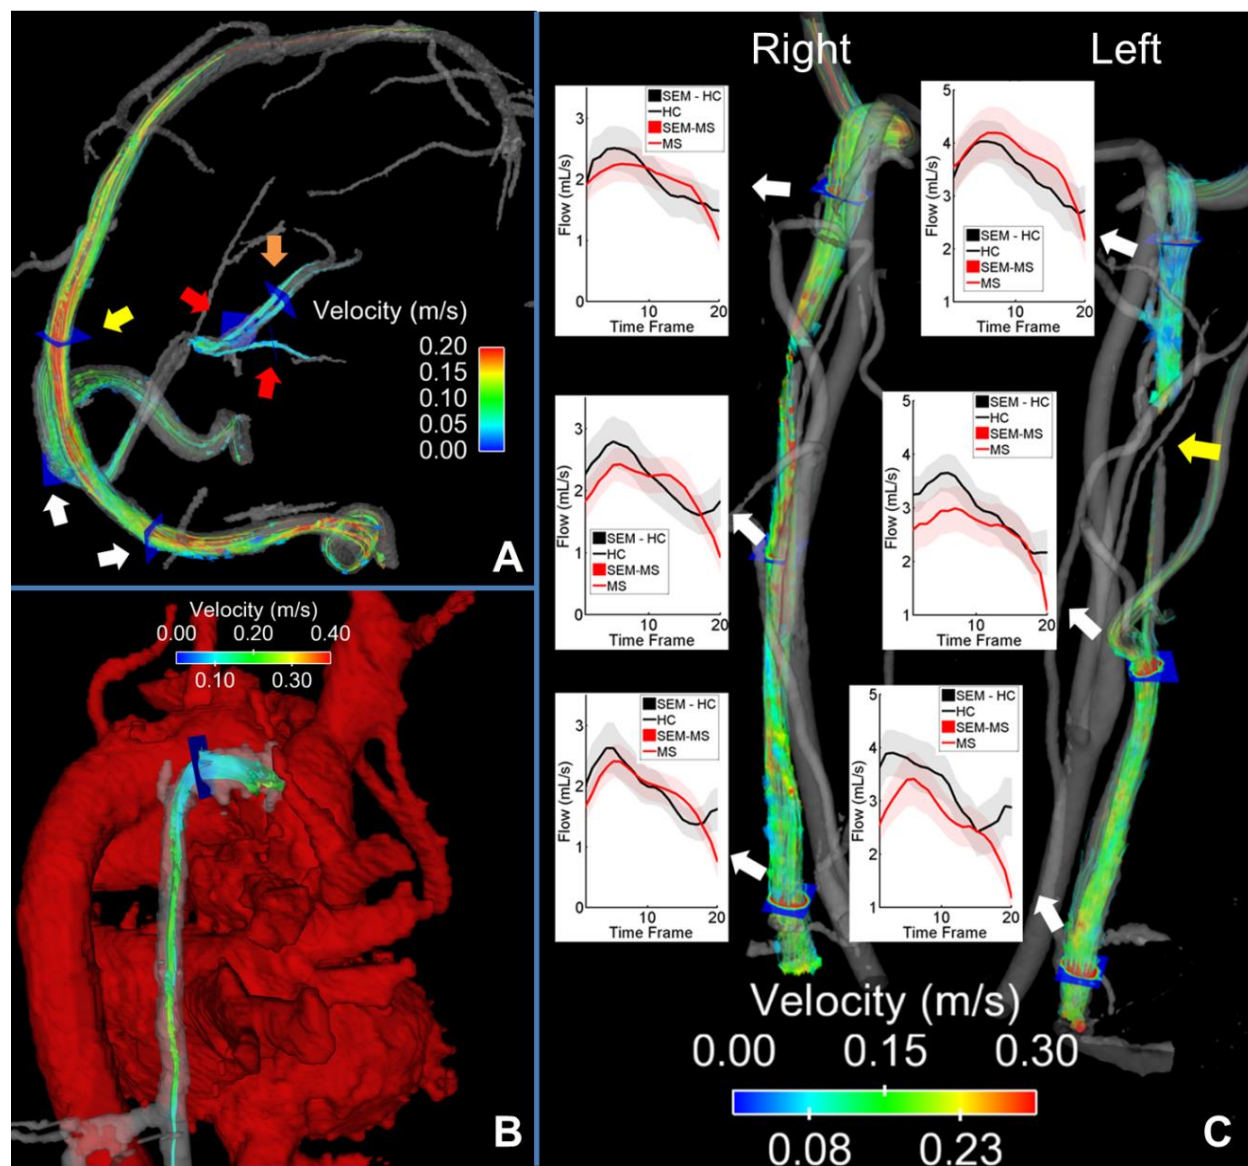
Measurement locations and example velocity streamline visualizations in the cerebrospinal vasculature. A – superior sagittal sinus (yellow arrow), left/right transverse sinus (white), left/right internal cerebral vein (orange), left/right basal vein (red); B – azygos vein with heart vasculature in red; C – left/right IJV at upper, mid, and lower. Inset shows average flow waveforms ( $\pm$  standard error of the mean, SEM) at these measurement locations between MS and HC. Note the apparent IJV stenosis observable with 4D flow MRI (yellow arrow).
